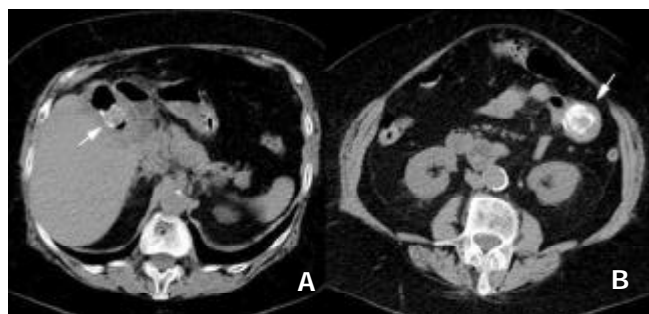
CT shows: A: A large, 5×3 cm, intraluminal stone (arrow) in the proximal jejunum, B: Another stone in the duodenal bulb (arrow).
